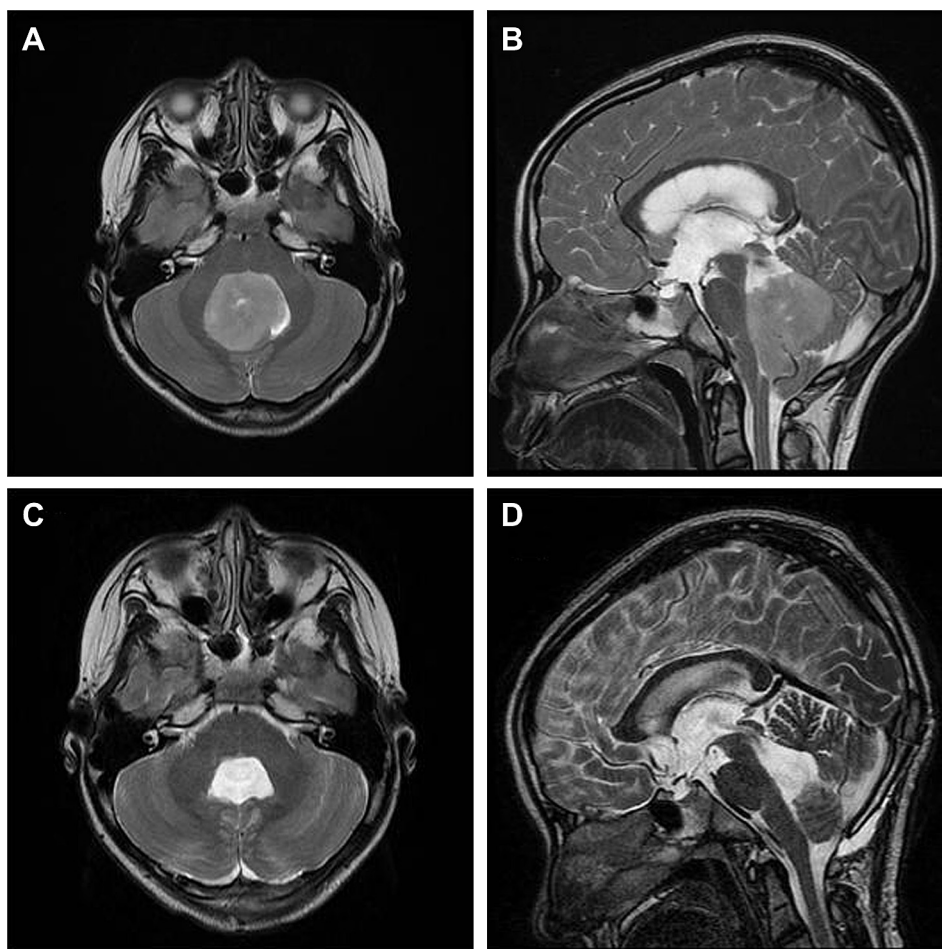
Pre- and postoperative brain magnetic resonance imaging of Case 1. (A and B) The preoperative brain scan shows a globular mass lesion measuring 4.3 cm × 4.4 cm × 3.8 cm in diameter in the fourth ventricle with obstructive hydrocephalus. Medulloblastoma has been documented by pathology. (C and D) The postoperative image shows near-total excision of the tumor and resolution of hydrocephalus.
